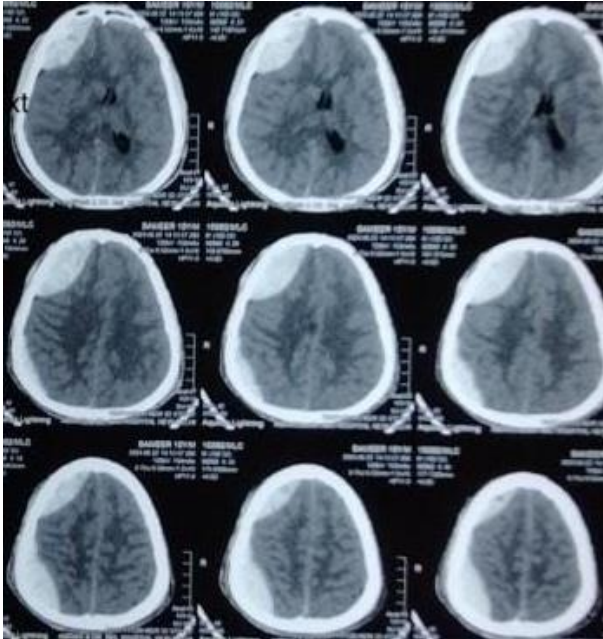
Non contrast CT head showing right frontal EDH of volume 44ml and right parietal EDH of volume 35ml causing mass effect and midline shift of 4.5mm to left.
